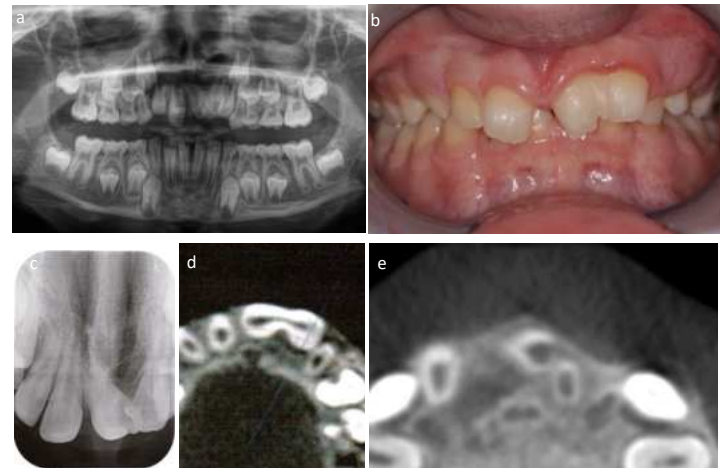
Preoperative clinical and radiographic situation (a-c). In the CBCT, the synodontia (d) and dens concreti (e) are evident in the occlusal sectional plane.
